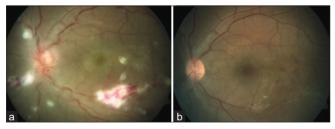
(a) This 21-year-old male patient with active retinal vasculitis was Mantoux positive, QuantiFERON tuberculosis gold positive with high resolution computed tomography chest showing features of pulmonary tuberculosis. (b) Resolution of retinal vasculitis after treatment with antitubercular therapy and steroid.
